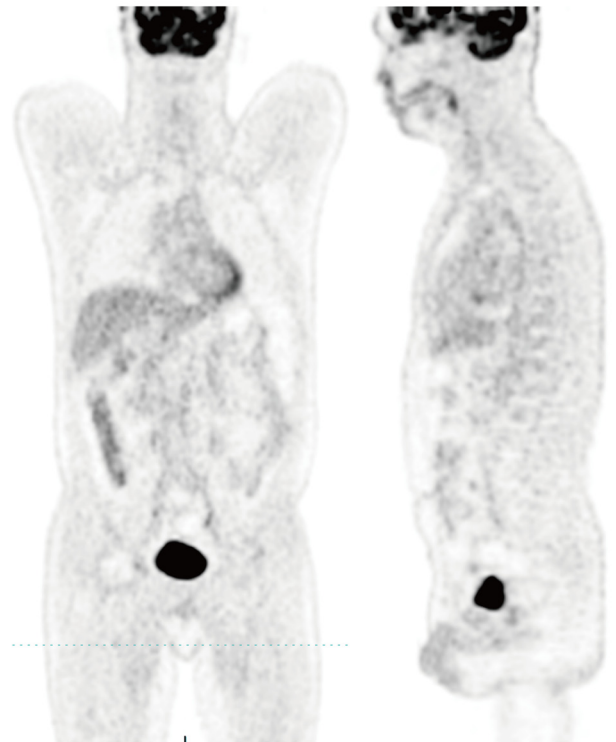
PET-CT showing complete response of the tumor (May 2018). PET-CT scans reveal the absence of detectable disease (no evidence of disease) following treatment, with no evidence of abnormal metabolic activity or residual tumor mass. PET-CT, emission tomography computed tomography.
